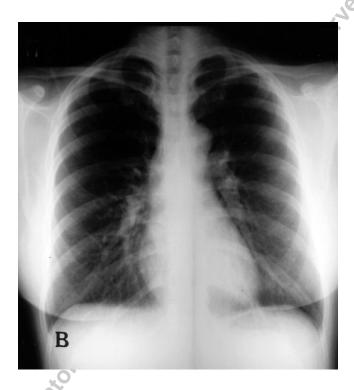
A. Chest radiograph showing bilateral pleural effusions on the day of admission. B. Followup radiograph one week later showing resolution of pleural effusion.
